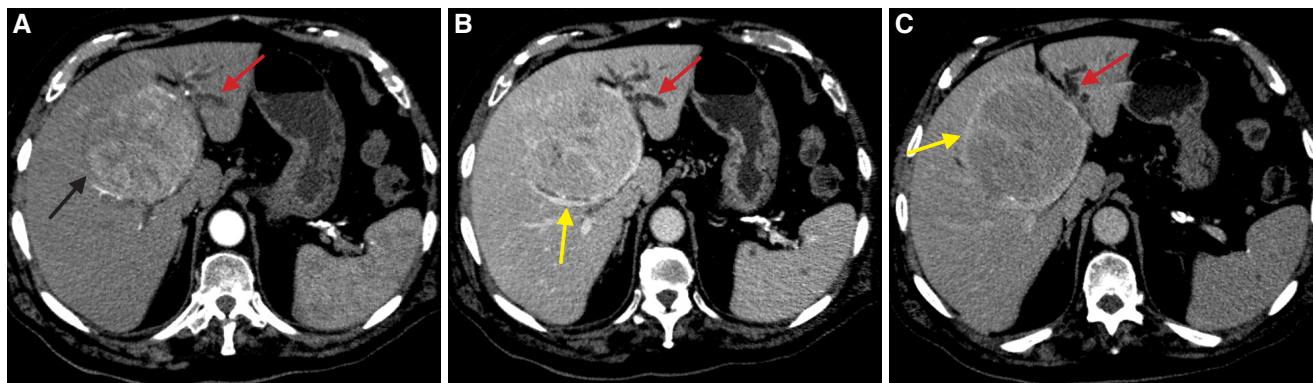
Computed tomography of axial planes obtained in arterial phase (A), portal phase (B), and late phase (C). Non-cirrhotic liver shows mass in right hepatic lobe (black arrow) with typical behavior of hepatocellular carcinoma. Heterogeneous enhancement in the arterial phase (A), and portal phase (B) with wash-out in delayed phase (C). The mass shows enhanced capsule in late phase (yellow arrow) and produces secondary dilatation of the bile duct (red arrow)
